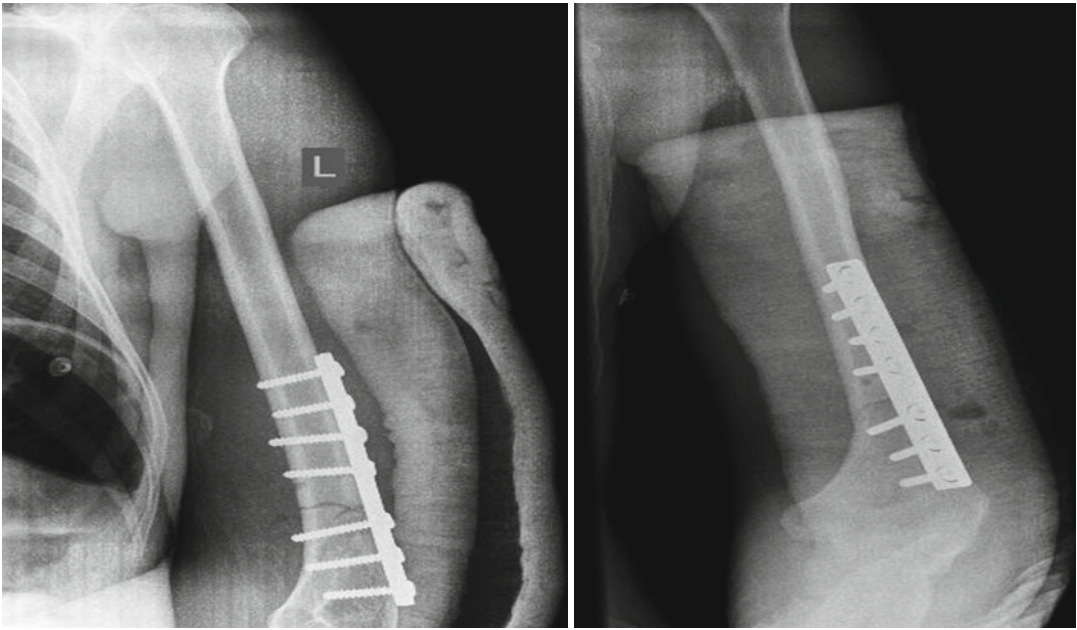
Postoperative X-ray of patient discussed in Case 2
